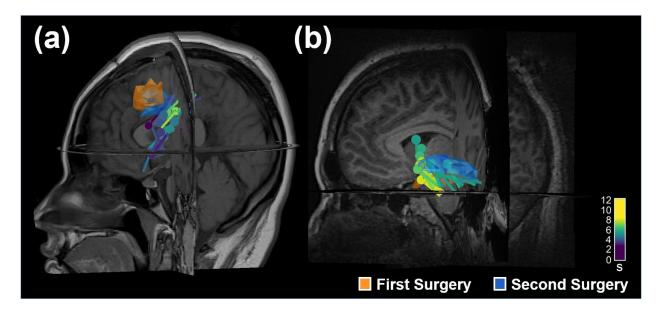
Dipole clustering and distance of dipoles from ablations. The magnetic resonance imaging (MRI) of an 18-year-old female (a) and 18-year-old male (b) who were seizure free after second resection guided by magnetoencephalography. Cluster of equivalent current dipoles (ECDs) from surgical volumes are displayed. ECDs are color-coded according to their clusterness: from low- (purple) to high-clusterness (yellow) values. The initial resection volume is orange-colored and the second resection volume is blue-colored.
